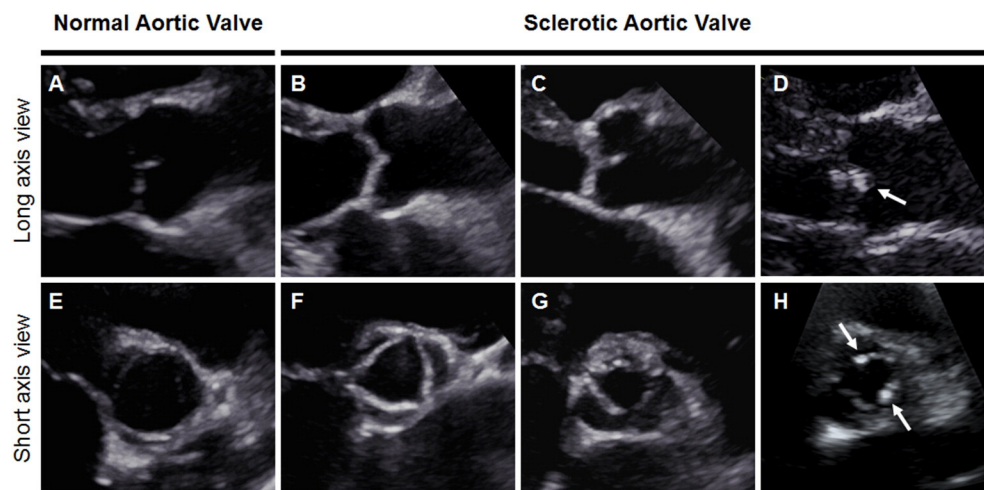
Representative transthoracic two-dimensional echocardiography. Normal aortic valve (A and E); slight thickness of the aortic valve leaflets (B and F); marked thickness of the aortic valve leaflets (C and G); fibrocalcific leaflets of the aortic valve (D and H). White arrows indicate possible calcium nodules. Upper panels represent images acquired in long axis view (diastole) and lower panels represent images acquired in short axis view (systole).
